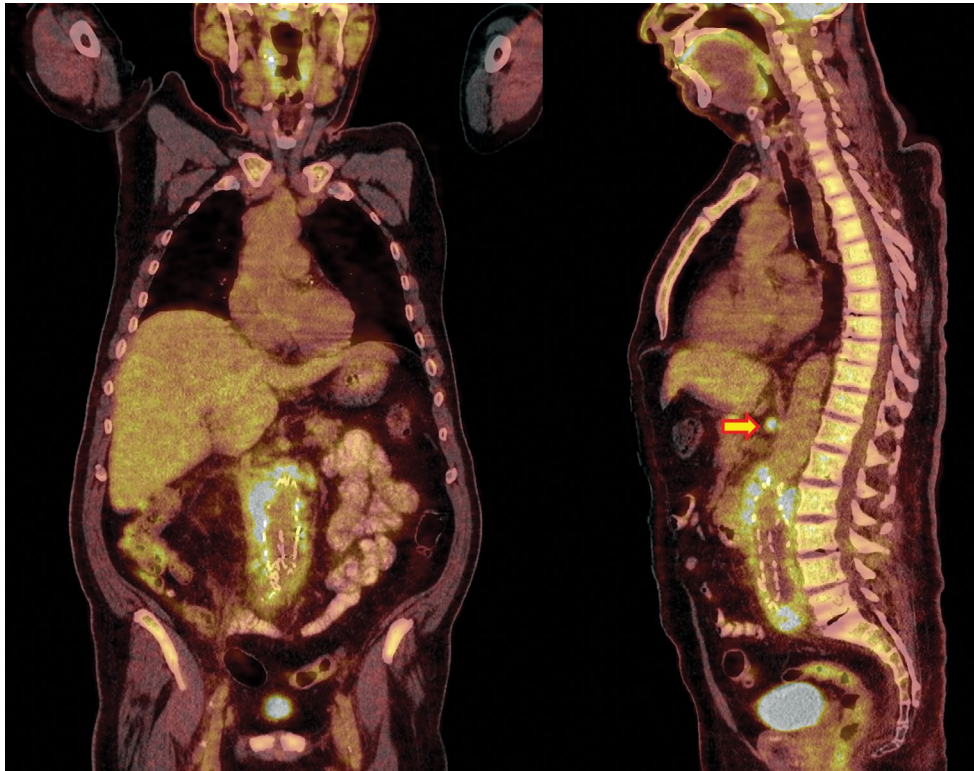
Increased ^{18}F -FDG uptake associated with irregular peri-graft soft tissue swelling and fluid retention around infected aortic stentgraft, demonstrated on coronal and sagittal projections of ^{18}F -FDG PET/CT. Infection in the paraaortic lymph node with high radiopharmaceutical activity (arrow)
